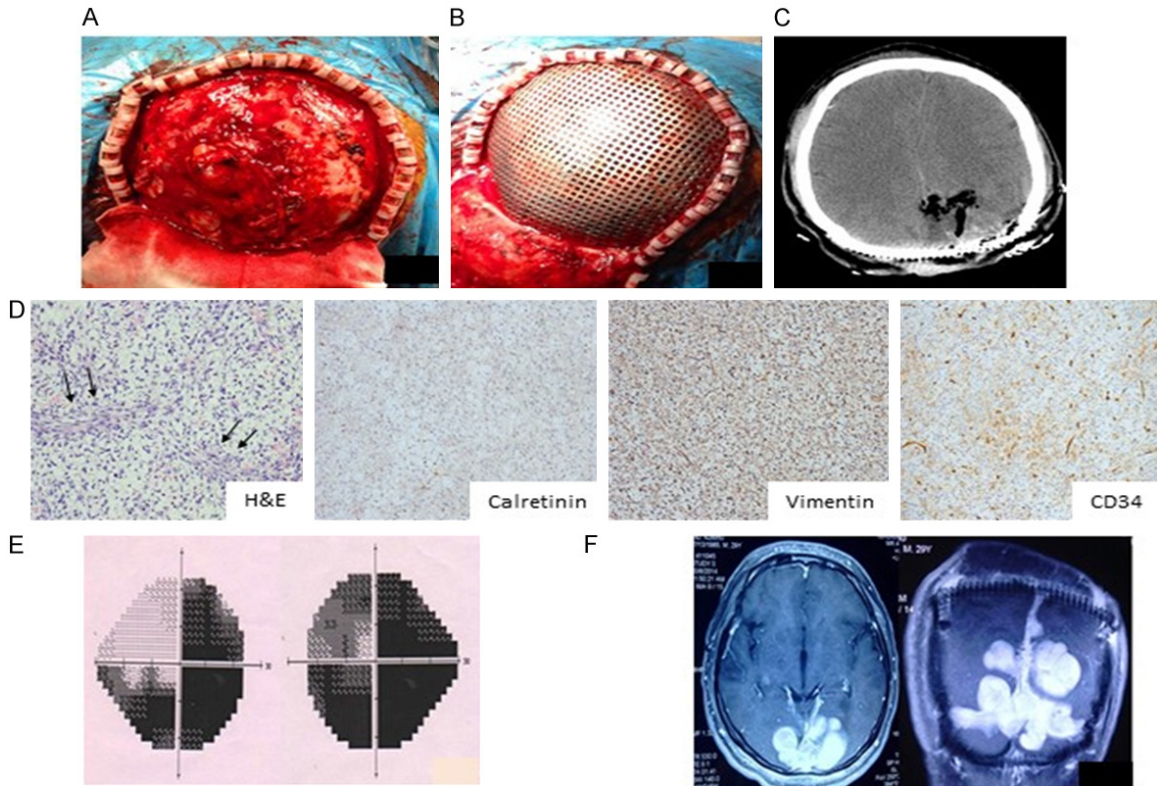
A. Photograph of the top of the patient's head during the operation shows bleeding and hemorrhages. B. Photograph of the top of the patient's head shows artificial meninges and pre-molded titanium mesh. C. CT imaging after the fourth surgery: a visible cavity after tumor mass removal with visible titanium mesh. D. IHC analysis of the tumor sections with 200 × magnification power. E. Final perimetry exam indicates extensive loss of vision (grey and dark area). F. Final MRI scan shows recurrence of tumor in patient's brain with strong contrast and 7.3 cm × 9.5 cm × 4.5 cm in size.
